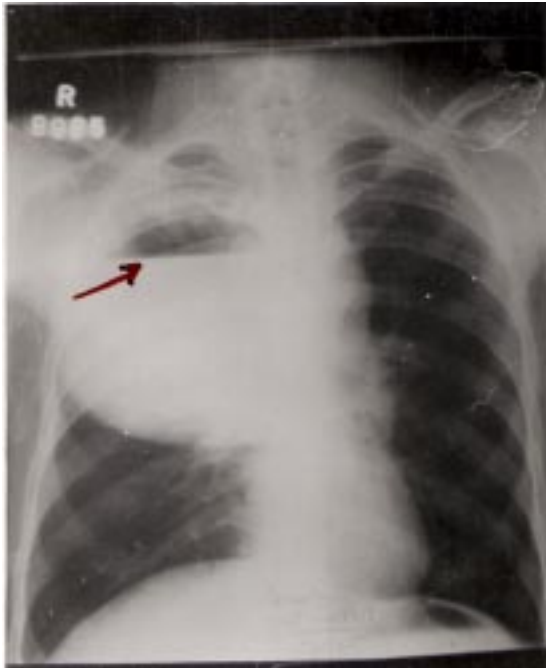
Chest radiograph (postero-anterior view) showing lung abscess on the right side with air-fluid level (arrow).
